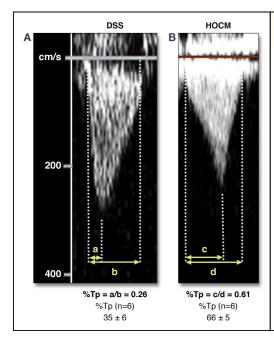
Continuous Wave Doppler Tracing of a Representative Case With DSS and HOCM Through the LVOT
